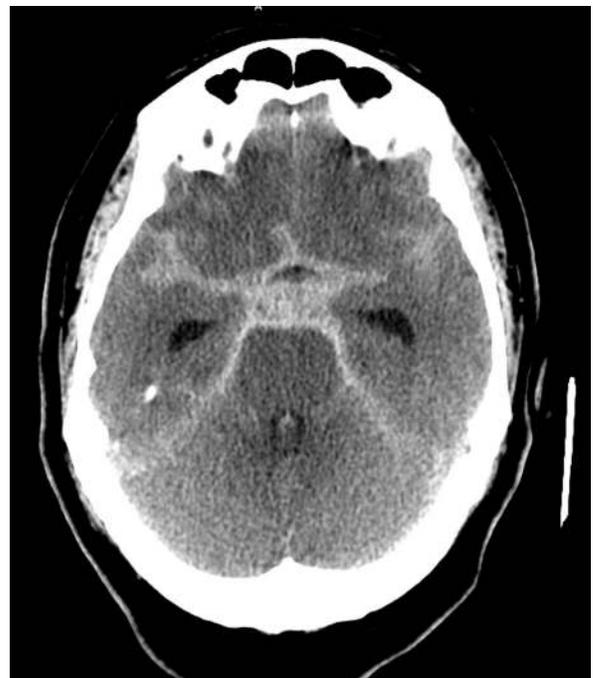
Characteristic CT Scan Showing Acute Aneurysmal Subarachnoid Hemorrhage with Blood in the Perimesencephalic Cisterns and Sylvian Fissures.
